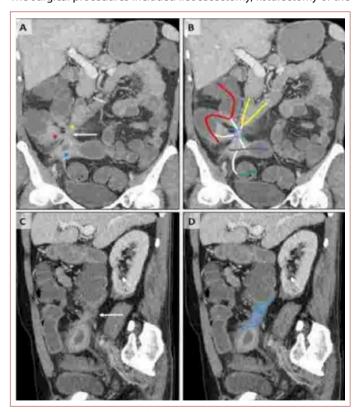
CT Enterography Findings. Coronal (A, B) and sagittal (C, D) MIP (Maximum Intensity Projection) images. Wall thickening and enhanced contrast are observed in the 2nd-3rd part of the duodenum (yellow star), terminal ileum (blue star), and cecum (red star) (A). The lumens of these structures, represented by the same colors, show connections with the sigmoid colon (green line) via tract-like structures (white lines) and fistulization (blue circle) (B). Sagittal images (C, D) reveal a thick-walled fistula tract (C, white arrow) and the fistula tract (D, blue area).
